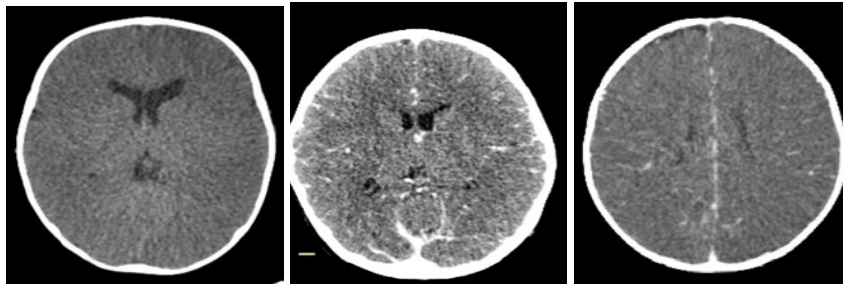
Suspected meningitis as a cause of new-onset seizures in the paediatric population. (a and b) Axial enhanced CT brain of a 1-year-old male: Basal and leptomeningeal enhancement with a ring-enhancing lesion apparent in the left cerebellar peduncle complicated by cerebral oedema with raised intracranial pressure demonstrated by splaying of the sutures (image not included) as well as communicating hydrocephalus with subependymal oedema. Tuberculous meningitis (TBM) with a tuberculoma was thought to be the most likely diagnosis. There was opacification of the mastoid air cells and middle ear cavities bilaterally (image not included) consistent with otomastoiditis. (c, d and e) Axial enhanced CT brain images in a 2-month-old female: Basal enhancement with multiple hypodensities involving the occipital lobes, thalami and basal ganglia bilaterally, left temporal lobe and left pons with associated hydrocephalus with ependymal oedema. A diagnosis of suspected complicated TBM was given.
